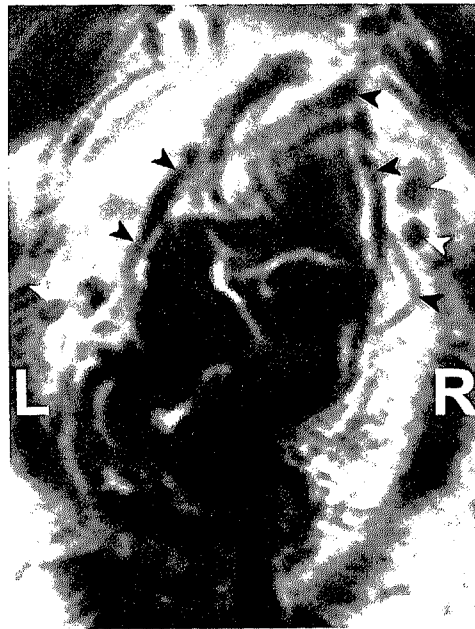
11. Coronal T2W FSE (TR/TE 3427/150 msec) MR images of a patient with rectal cancer show the superior rectal artery and its branches (black arrowheads). Also small hypointense lymph nodes are depicted (white arrowheads).
